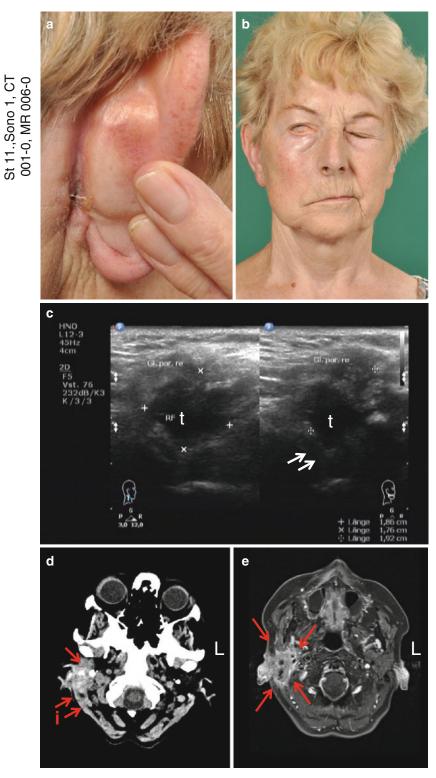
Parotid carcinoma of the right side with facial palsy. (a) Skin infiltration of the tumor behind the right ear. (b) Complete facial palsy on the affected right side. (c) Ultrasonography of the right parotid and of the tumor (*t*) cannot show the infiltration of the surrounding tissue
